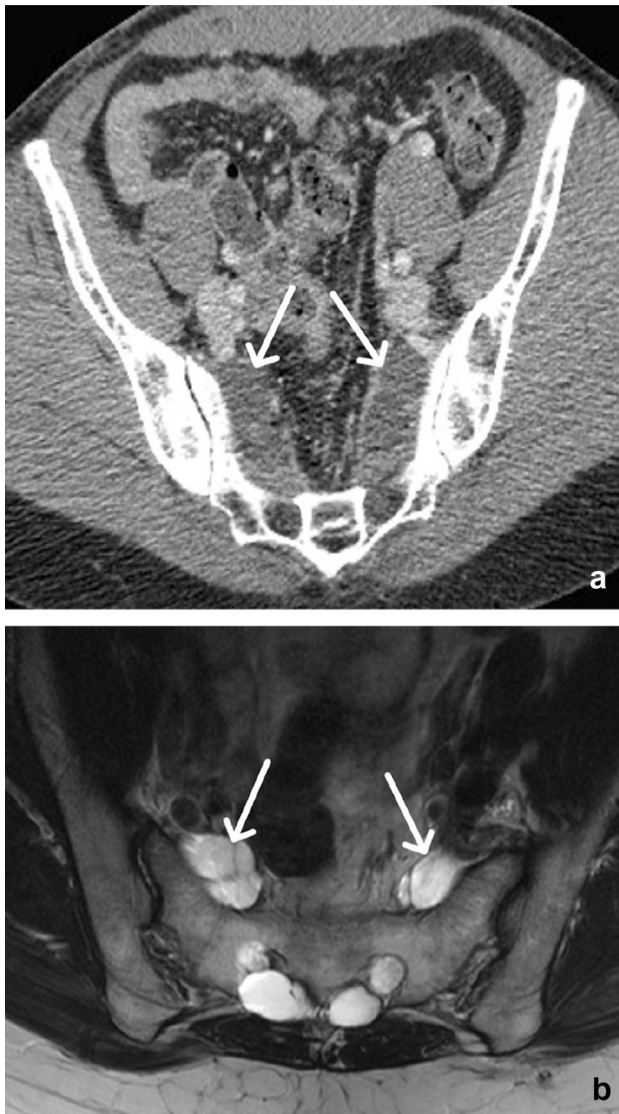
42-year-old male with perineural (Tarlov) cysts. Axial contrast-enhanced CT (a) and T2W MR (b) images demonstrate CSF attenuation and signal intensity in simple cystic structures closely related to the sacral and lower lumbar nerves without evidence of enhancement (arrows). The sacral foramina are mildly enlarged
